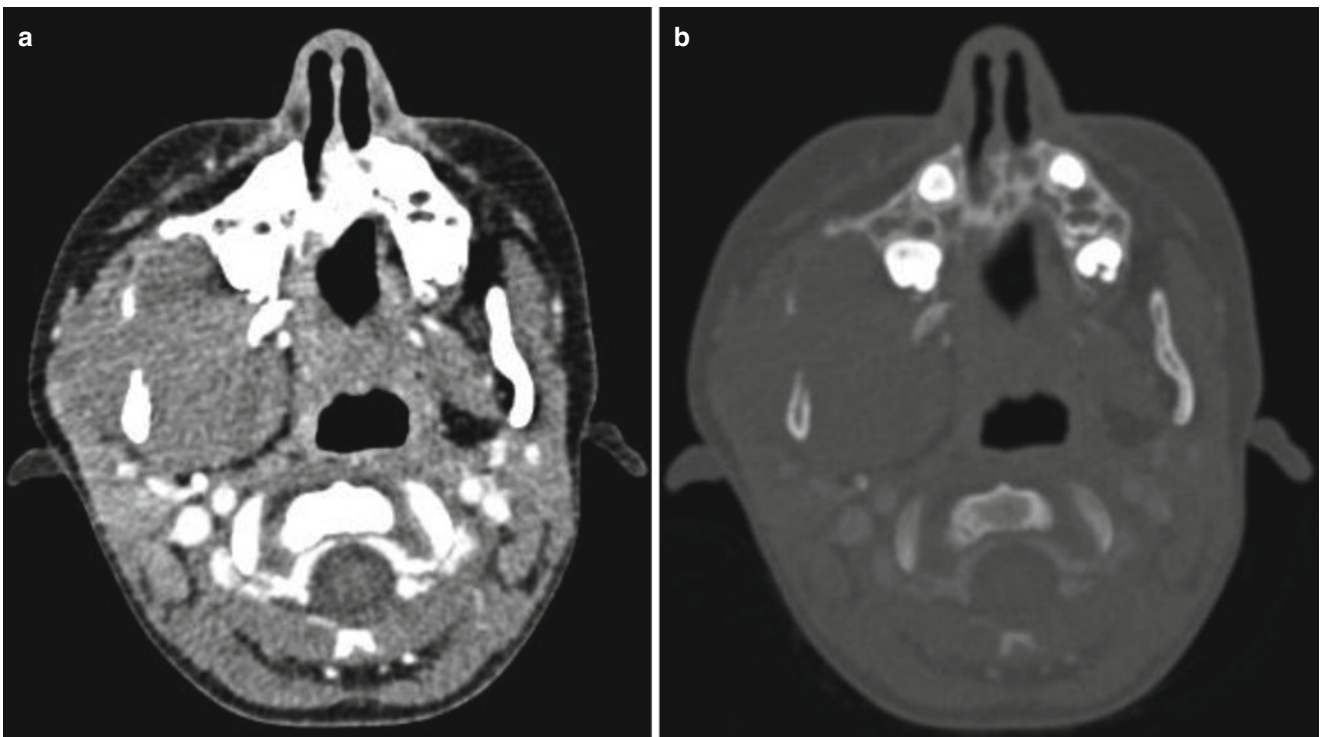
Burkitt's lymphoma. Facial CT showing a large soft tissue mass arising from the ramus of the right mandible (a), causing bone destruction, best seen on bone window settings (b). The appearances are typical for Burkitt's lymphoma
